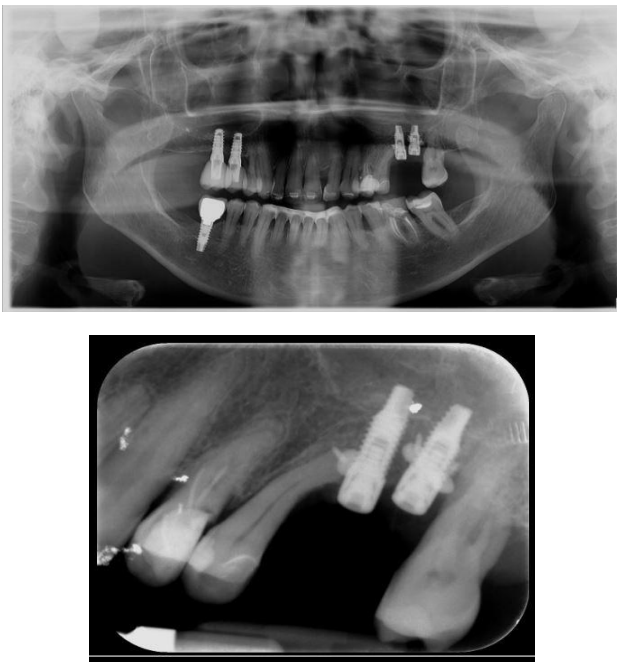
Initial intraoral X-ray and OPT 2018 prior to prosthetic loading.
